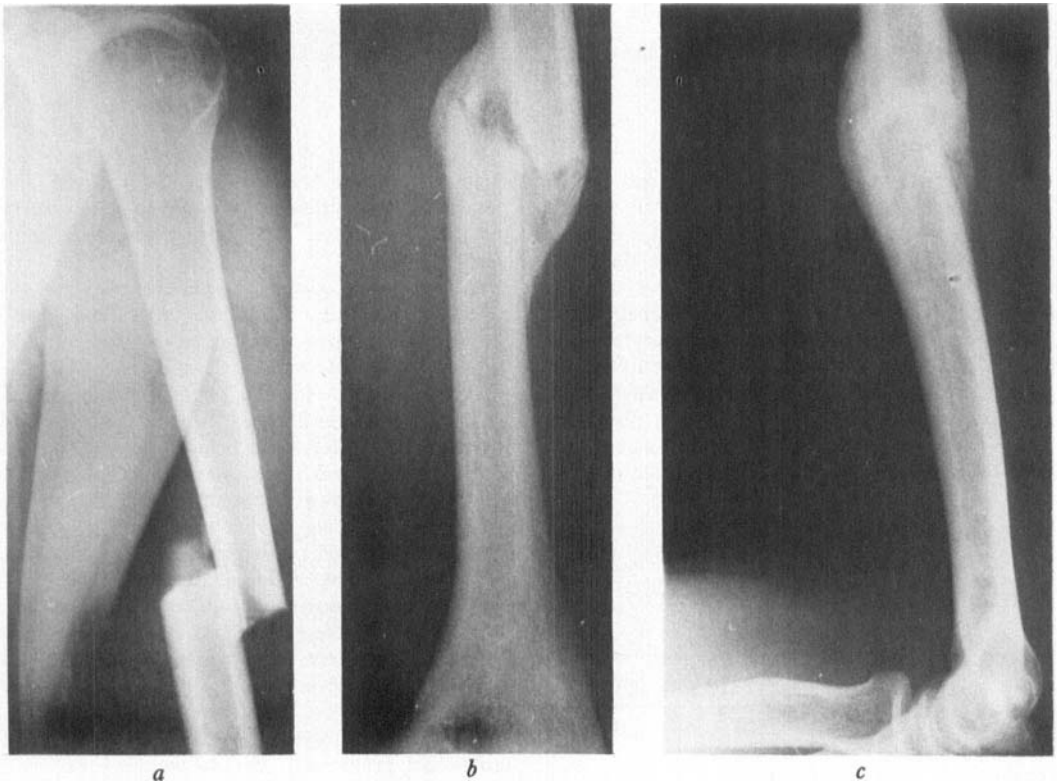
(a) Transverse fracture of the left humerus (August 13) in a 20-year-old lumberjack. Shortening of 2 cm. (b, c) X-rays of the same patient 2 months later when he returned to work. By October 3 he could lift weights of 5 kg above his head.
